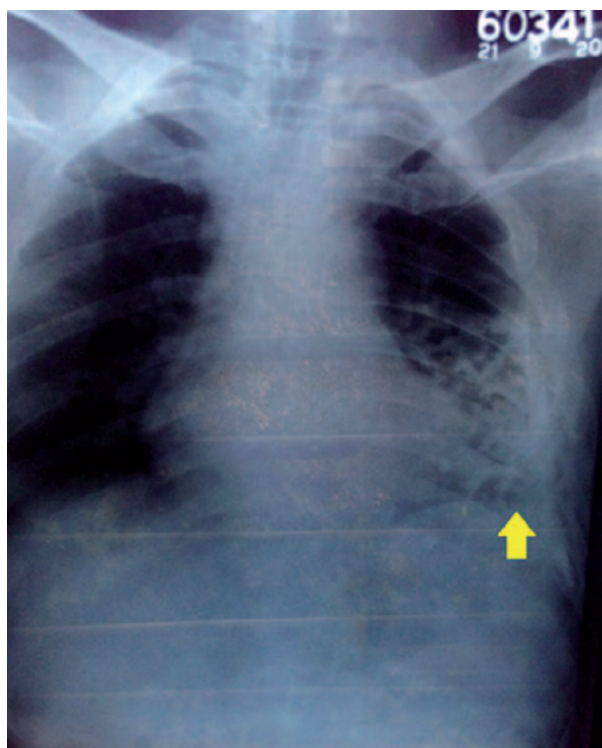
Chest radiograph showing multiple calcifications in the left lower zone with some overlapping the pericardium (yellow arrow)
